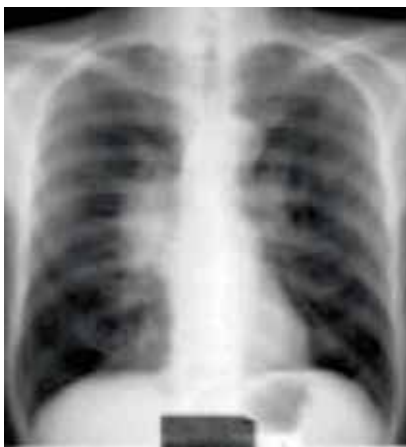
A chest x-ray showing enlarged
